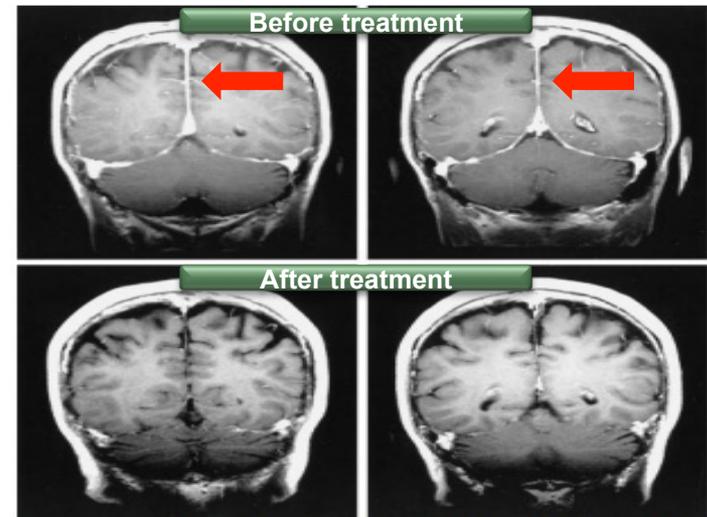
Patient 6. Gadolinium-enhanced T1-weighted brain MR images obtained before (top) and after (bottom) treatment show disappearance of dural enhancement
